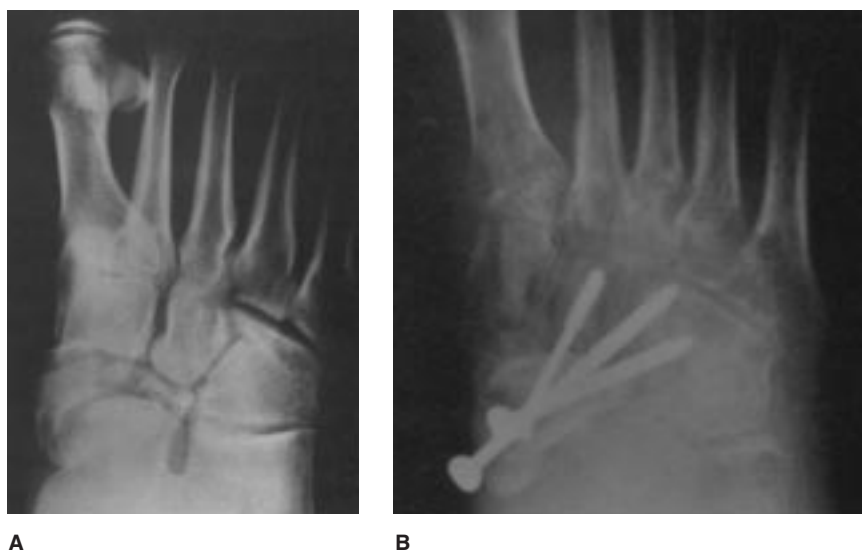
Preoperative (A) and postoperative (B) radiographs showing a type 3 injury treated with ORIF. Note that major fragments were secured to the cuneiforms. (Reproduced with permission from Sangeorzan BJ, Benirschke SK, Mosca V, Mayo KA, Hansen ST Jr: Displaced intra-articular fractures of the tarsal navicular. *J Bone Joint Surg Am* 1989;71:1504-1510.)
